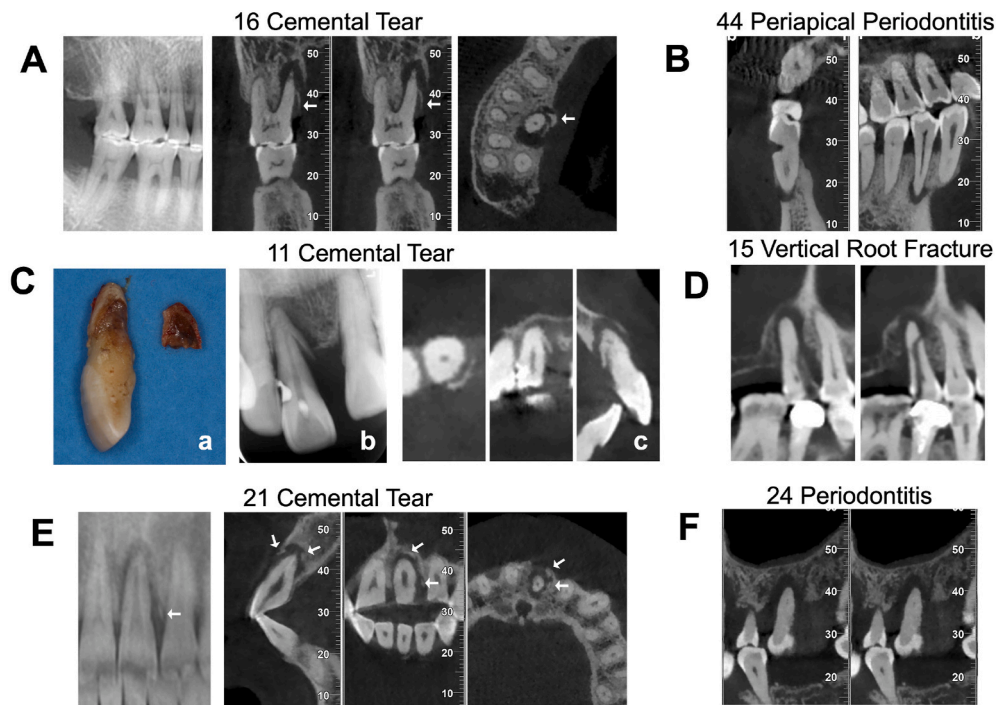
Representative images depict cemental tear, periapical periodontitis, vertical root fracture, and periodontitis. A: Cemental tear on the palatal root of tooth 16, showing periapical radiolucency with no coronal lesion. B: Tooth 44 with periapical radiolucency and wedge-shaped lesion involving the pulp chamber. C: a. Extracted tooth 11 with detached cementum; b. Plain X-ray of tooth 11 displaying a crack between cementum and dentin; c. CBCT of tooth 11 revealing a crack between cementum and dentin (detached cementum). D: Tooth 15 with vertical root fracture, displaying a crack inside dentin. E: Tooth 21 showing detached cementum on the buccal and distal sides of the root (right, white arrows) with surrounding radiolucency. Only cementum on the distal side of the root is visible on the 2D image (left, white arrow). F: Tooth 21 with periodontitis exhibiting radiolucency around the root. CBCT: cone beam computerized tomography.
